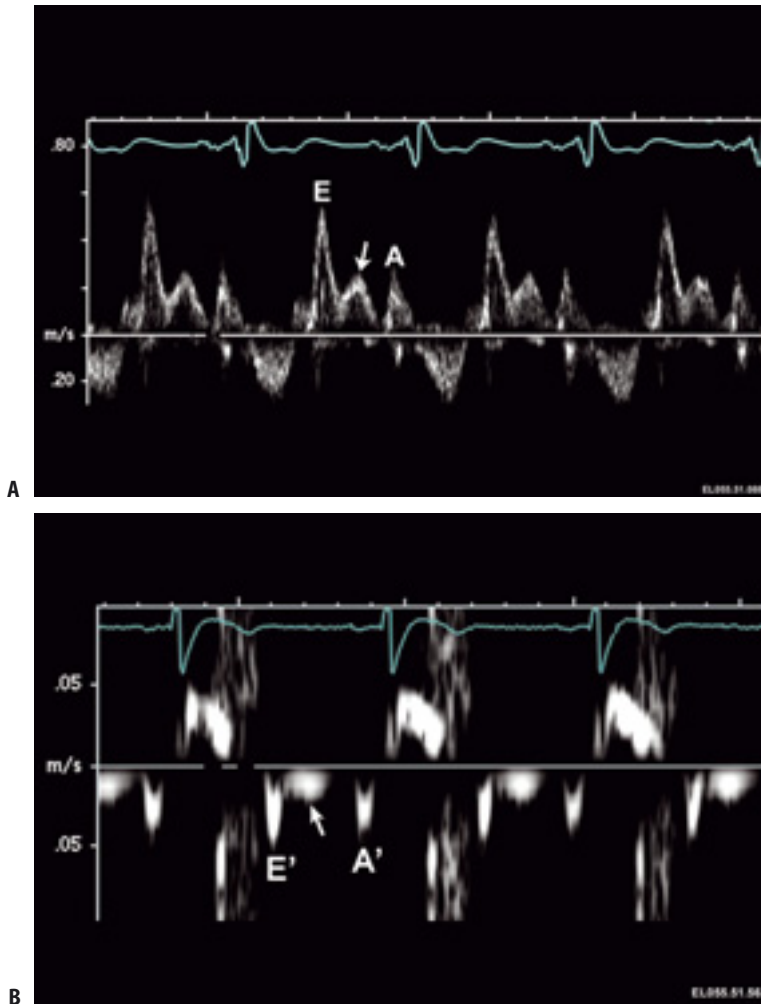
(A) Pulsed wave Doppler recording of mitral inflow velocity demonstrating mid diastolic flow (arrow) between E and A velocities. Mid diastolic flow velocity represents markedly delayed myocardial relaxation. This pattern usually indicates advanced diastolic dysfunction with at least moderately increased
